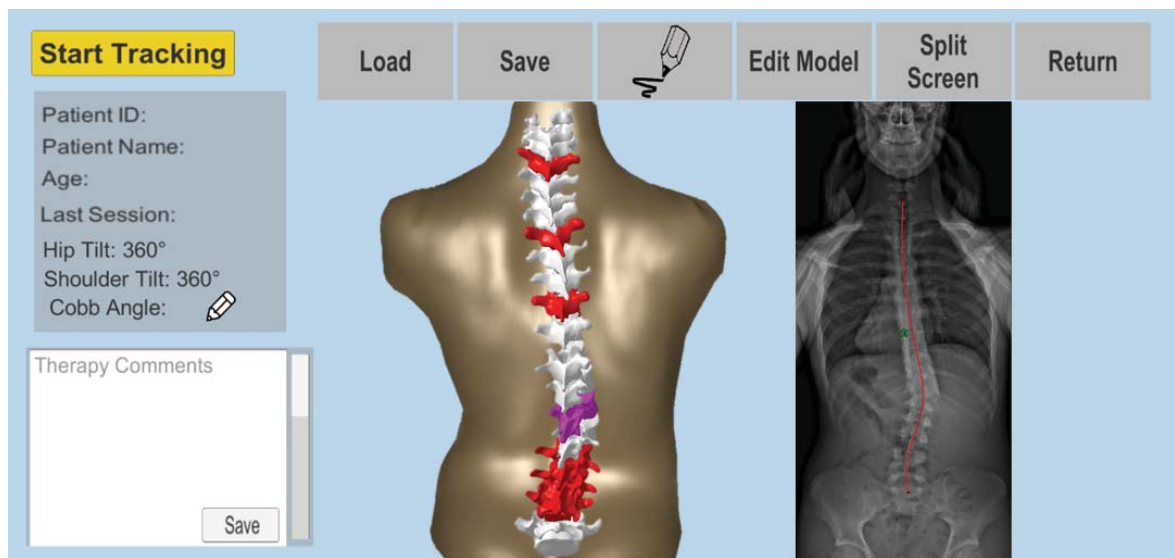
GUI of the ARScoliosis application for 3D visualization, diagnosis and archiving records on subject specific posture or spinal pathologies including another modalities e.g. X-ray image.
